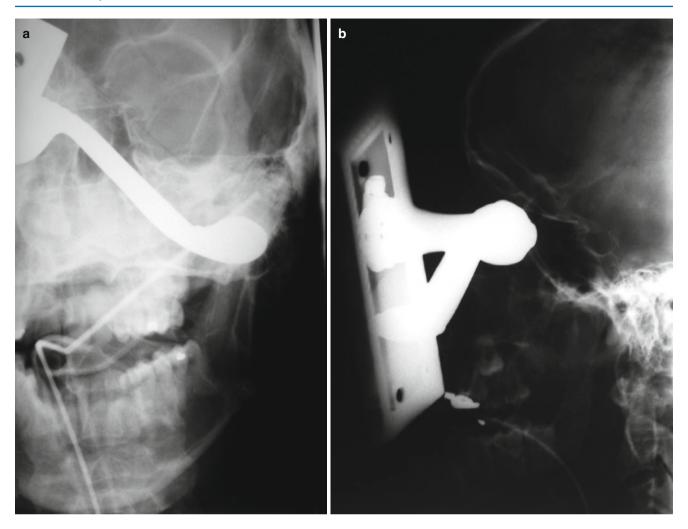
Its position and size are determined radiographically (also using CT) (a, b)
